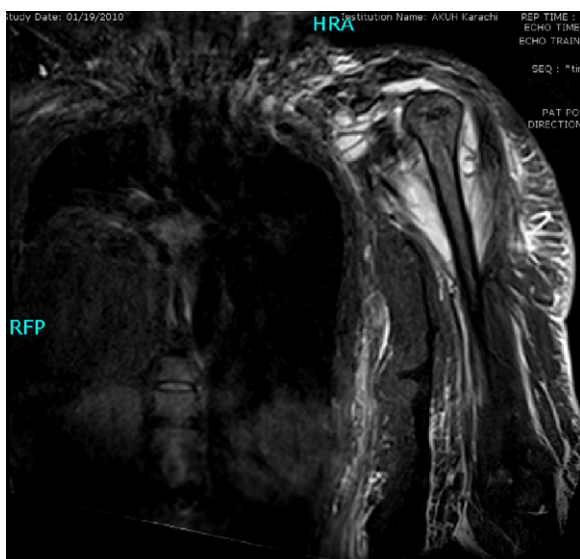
MRI scan of left shoulder showing purulent collection in left shoulder and chest wall travelling down along proximal humerus.
